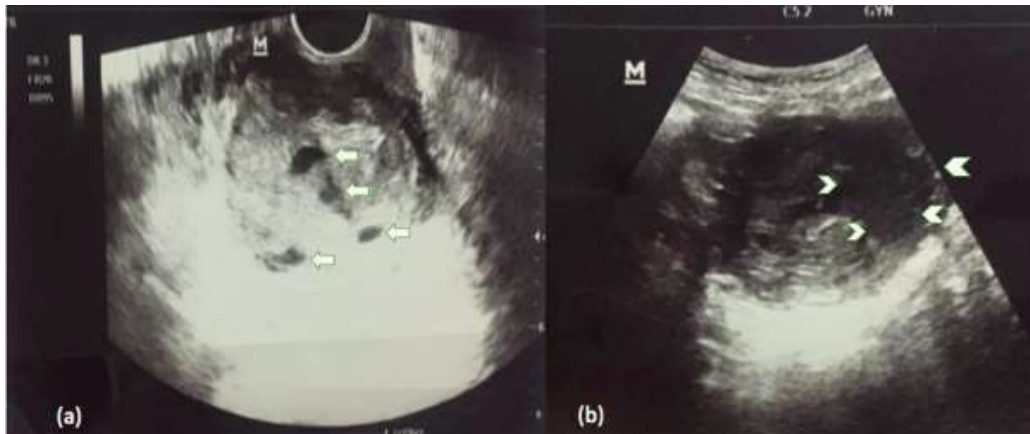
(a) Transvaginal scan shows multiple tubular hypoechoic structures at the uterine wall (white arrows). (b) Transabdominal scan shows a hypoechoic lesion noted at the left side of the uterine wall which raised the suspicion of uterine mass or if correlating with the tubular-like structure in (a), this raised the suspicion of a possible uterine AVM nidus (arrowheads) A contrast-enhanced CT of the pelvis (Figure 2) showed tortuous dilated vessels noted at the parametrium around the uterus with some seen traversing the hypodense lesion. There is a hypodense lesion arising from the left anterolateral wall of the uterus measuring 5.7 × 8.6 × 5.4 cm (AP × W × CC). No calcifications were noted within. Both ovaries are normal. The tortuous dilated vessels raised the suspicion of uterine arteriovenous malformation while the hypodense lesion may represent a uterine fibroid.
